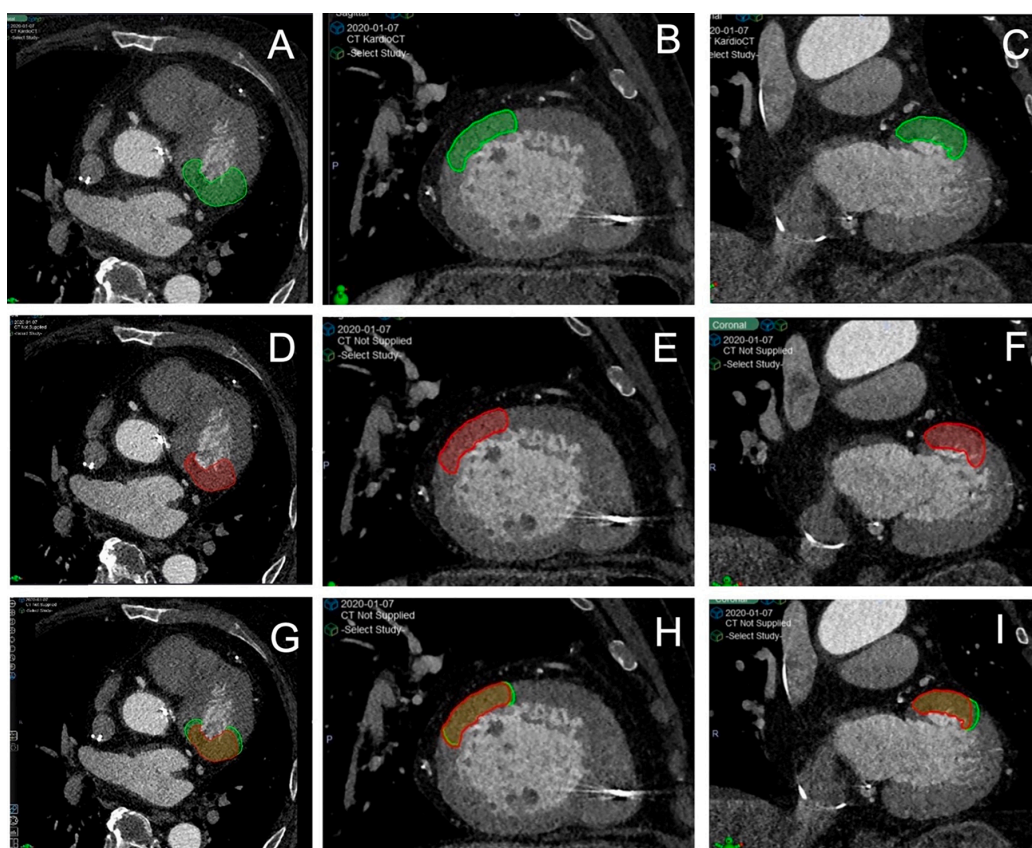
Axial, sagittal and coronal views of cardiac computed tomography with a representative transferred transmural cardiac clinical target volume (CTV). (A-C) CTV transferred by EAMapReader 3D-3D registration (green). (D-F) CTV transferred by CARDIO-RT 2D-3D registration (red). (G-I) Overlay both CTV structures.
